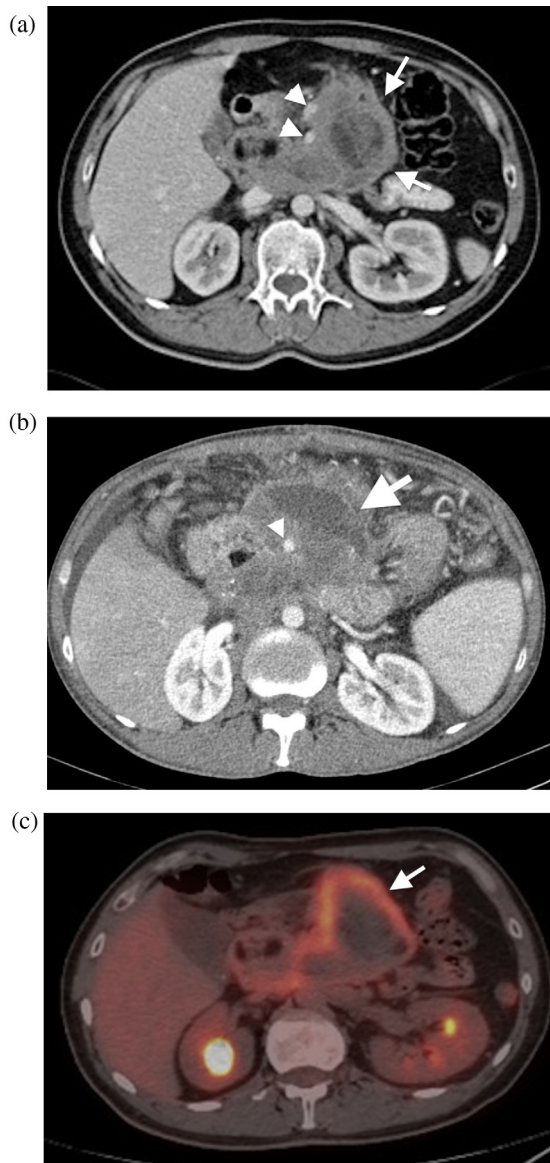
Mesenteric mass secondary to IgG4-related disease. (a) Axial contrast-enhanced CT demonstrates a fibrofatty mass (arrows) localized in the mesentery, anterior to the abdominal aorta and inferior vena cava. The mass encompasses the mesenteric vessels (arrowheads). (b) Mesenteric mass (arrow) encircles but does not invade superior mesenteric artery (arrowhead). (c) PET-CT reveals avid peripheral enhancement (arrow) in the abdominal mass mimicking malignancy with a SUV max value of 8.1.
